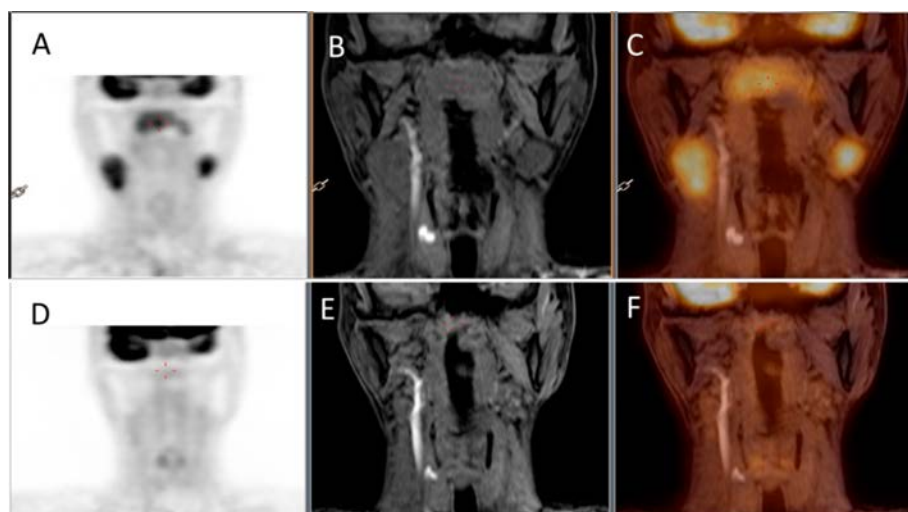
Images for a 52-year-old male with nasopharyngeal carcinoma confirmed by pathology with bilateral neck lymph node metastasis. It can be detected by PET (A), MRI (B), and PET/MRI before therapy. After two months of therapy, ^{18}F -FDG uptake was significantly decreased in PET (D) and PET/MRI (F), while the nasopharyngeal lesion and neck lymph node was also significantly reduced when detected by MRI (E).
